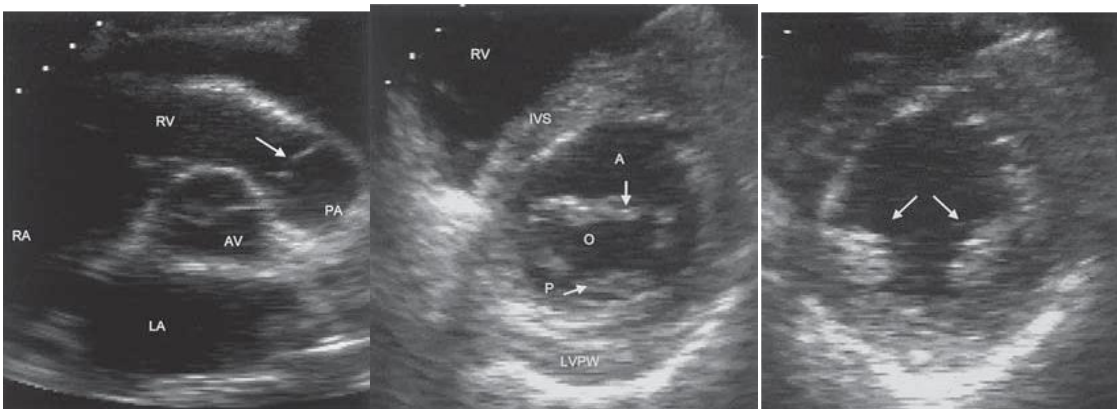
Parasternal short-axis views: (a) Aortic valve level. The pulmonary valve is shown (arrow). (b) Mitral valve level. The anterior (A) and posterior (P) leaflets are shown. Mitral orifice (O). (c) Papillary muscles (arrows) level.
